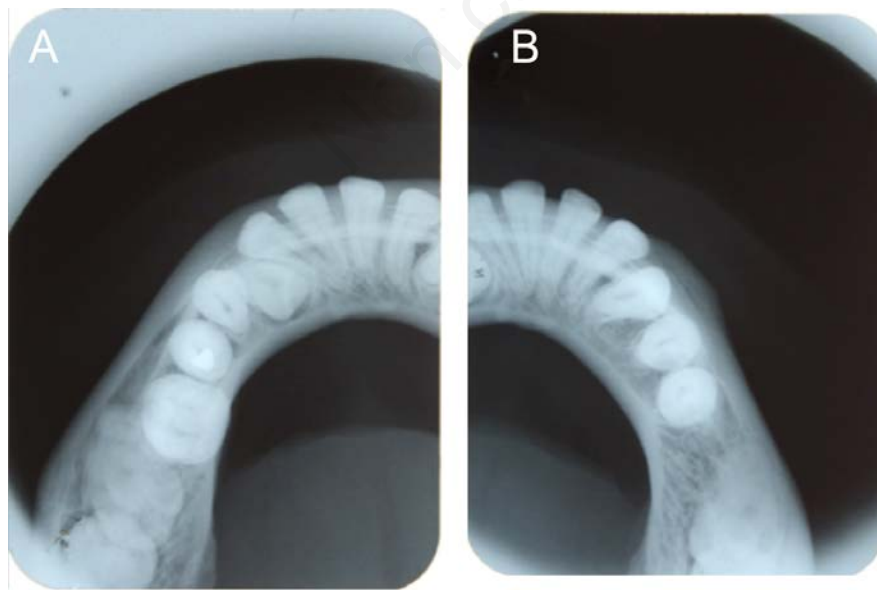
Occlusal radiograph of A) mandibular right quadrant and B) mandibular left quadrant.
